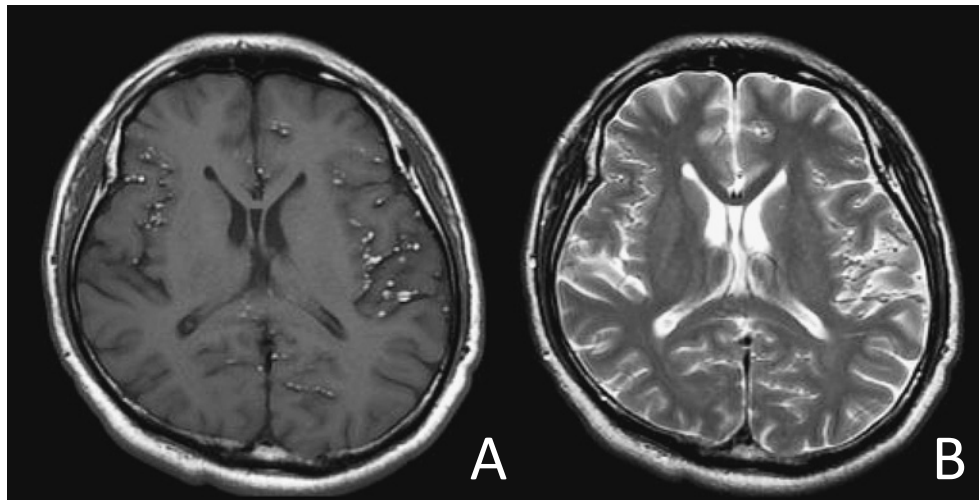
MRI scan acquired at the same time as that in Fig. 2.
